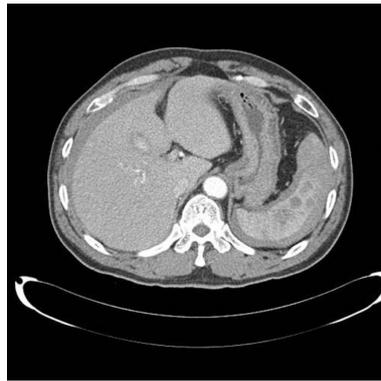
Computed tomography shows multiple hemorrhagic cysts in the spleen and a moderate amount of hemoperitoneum.
